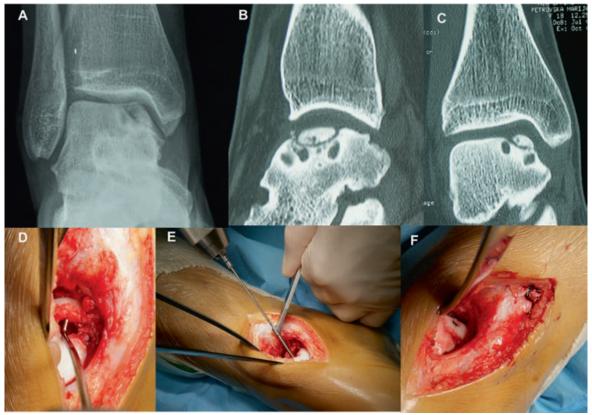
(A) X-ray with visible medial OCD on the talar dome. (B, C) CT confirms OCD with underlying bone and cystic lesions around it. (D) After medial malleolus osteotomy, the OCD is lifted, submitted to bone marrow
